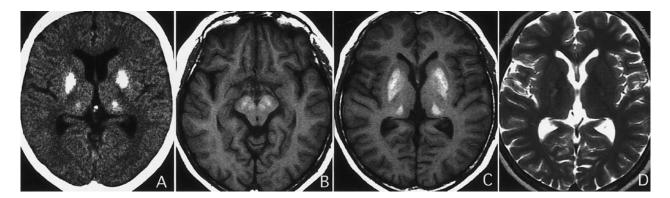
Case 2. (A) CT scan showing calcification of bilateral basal ganglia and thalami bilaterally. T1-weighted images of MR showing paradoxical high signal intensity area on both sides in red nucleus, substantia nigra, basal ganglia and thalamus (B and C). Calcification in the midbrain was not visible on CT scan. T2-weighted image of MR showing slightly decreased signal intensity areas in basal ganglia and thalami bilaterally
